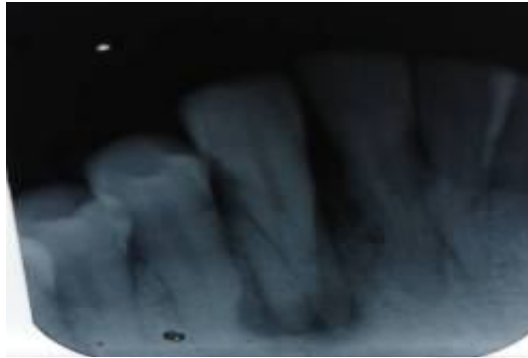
Pre-Operative radiograph showing two canals with two roots
